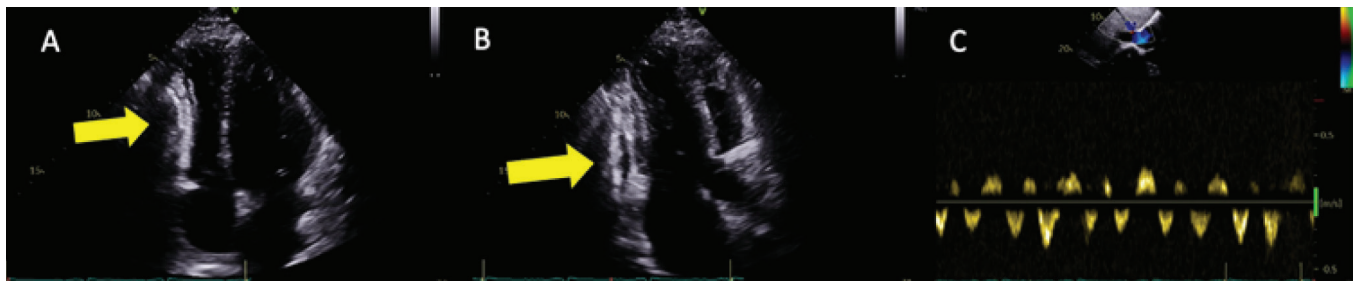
A. The four-chamber view of the heart showed calcified pericardium with a septal bounce phenomenon B. Three chamber view of the heart showed calcified pericardium. C. Doppler ultrasound showed reverse flow in the hepatic veins.
